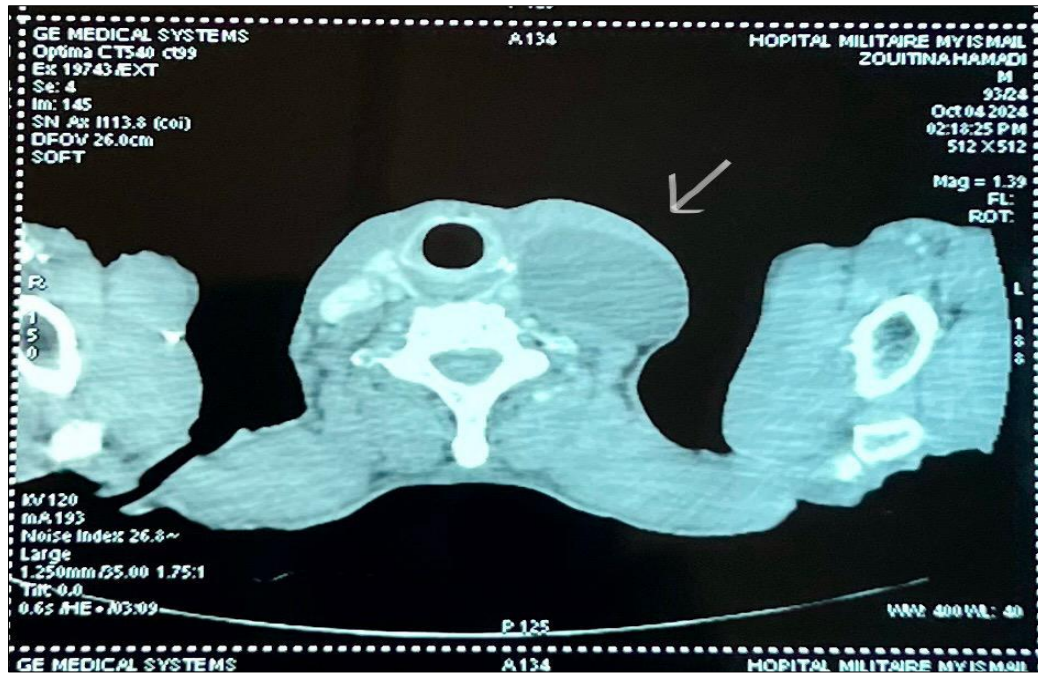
axial CT section showing a uni-loculated cystic lesion in the left subclavicular region extending to the left deep cervical spaces
